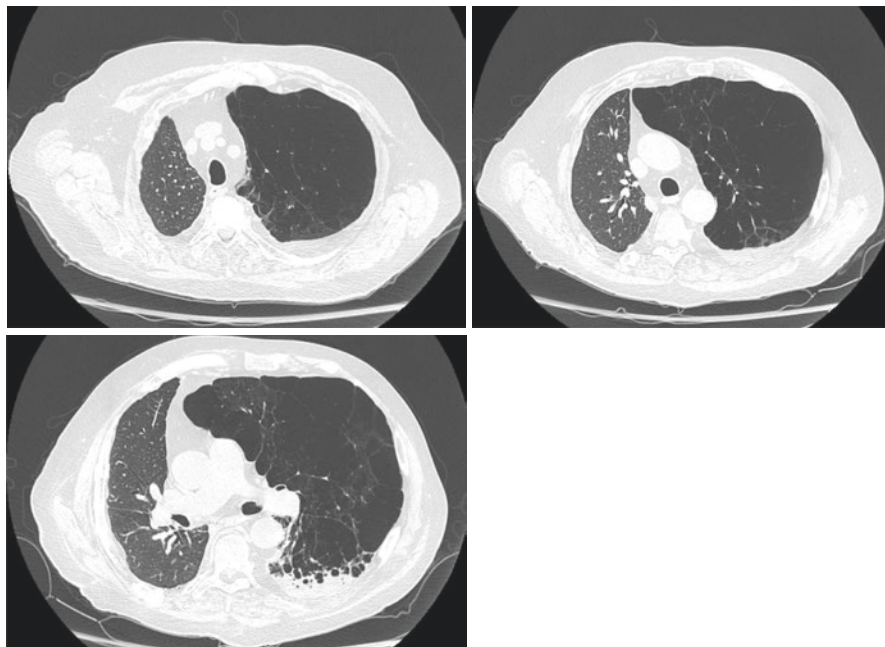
(a–c) A 71-year-old male with severe emphysema underwent SLT. Serial axial CT images through the chest (a–c) demonstrate rightward deviation of the mediastinum with resultant compression of the transplanted right lung by the severely emphysematous and hyperinflated native left lung
